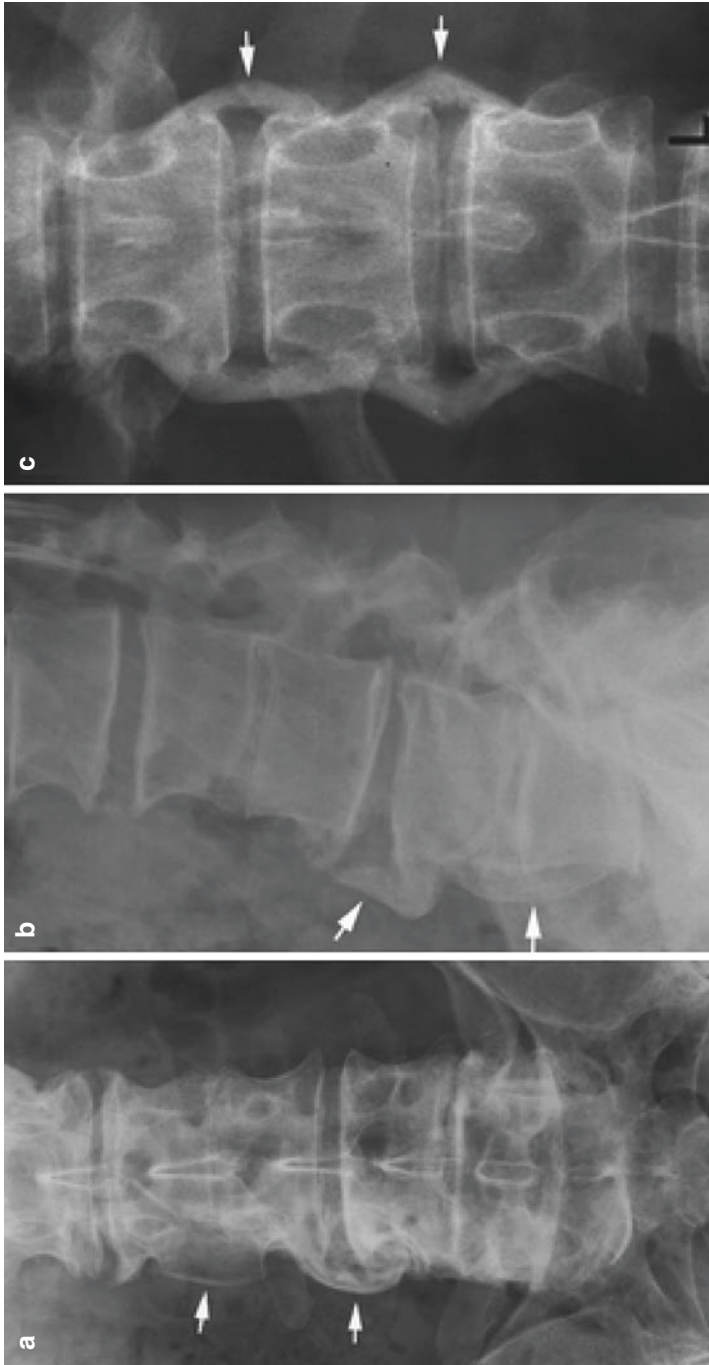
A 48-year-old man with PsA; (a and c) and (b) lateral radiographs of the lumbar spine notable for characteristic syndesmophytes (arrows) which are more voluminous and laterally projecting than those of AS [6]
